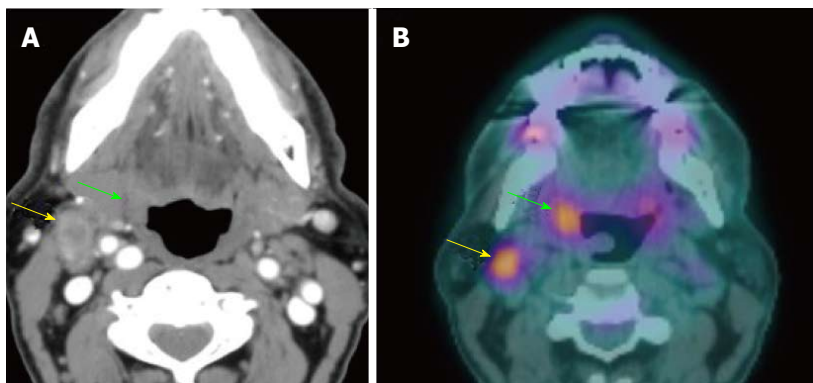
Occult squamous cell carcinoma of the right palatine tonsil. The lesion (green arrow) was not appreciated on physical examination, flexible endoscopy and contrast-enhanced CT (A), but demonstrated hypermetabolic activity on PET/CT with maximal SUV: 3.5 (B). Biopsy directed by PET/CT revealed squamous cell carcinoma of the right palatine tonsil. The right level IIA lymphadenopathy also showed increased FDG uptake (yellow arrow). The patient remained disease free for 5 years after treatment. PET/CT: Positron-emission tomography/computed tomography; SUV: Standardized uptake value; FDG: 2-fluoro-2-deoxy-D-glucose.
